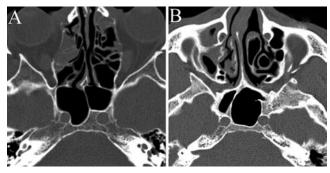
Axial CT images obtained in 2 patients with acromegaly. A: Note the caliber of the ICAs, asymmetrical sphenoid sinus septum, and thickened skull base. B: Note the deviated nasal septum, asymmetrical sphenoid sinus anatomy, and thickened sphenoid sinus septum.
